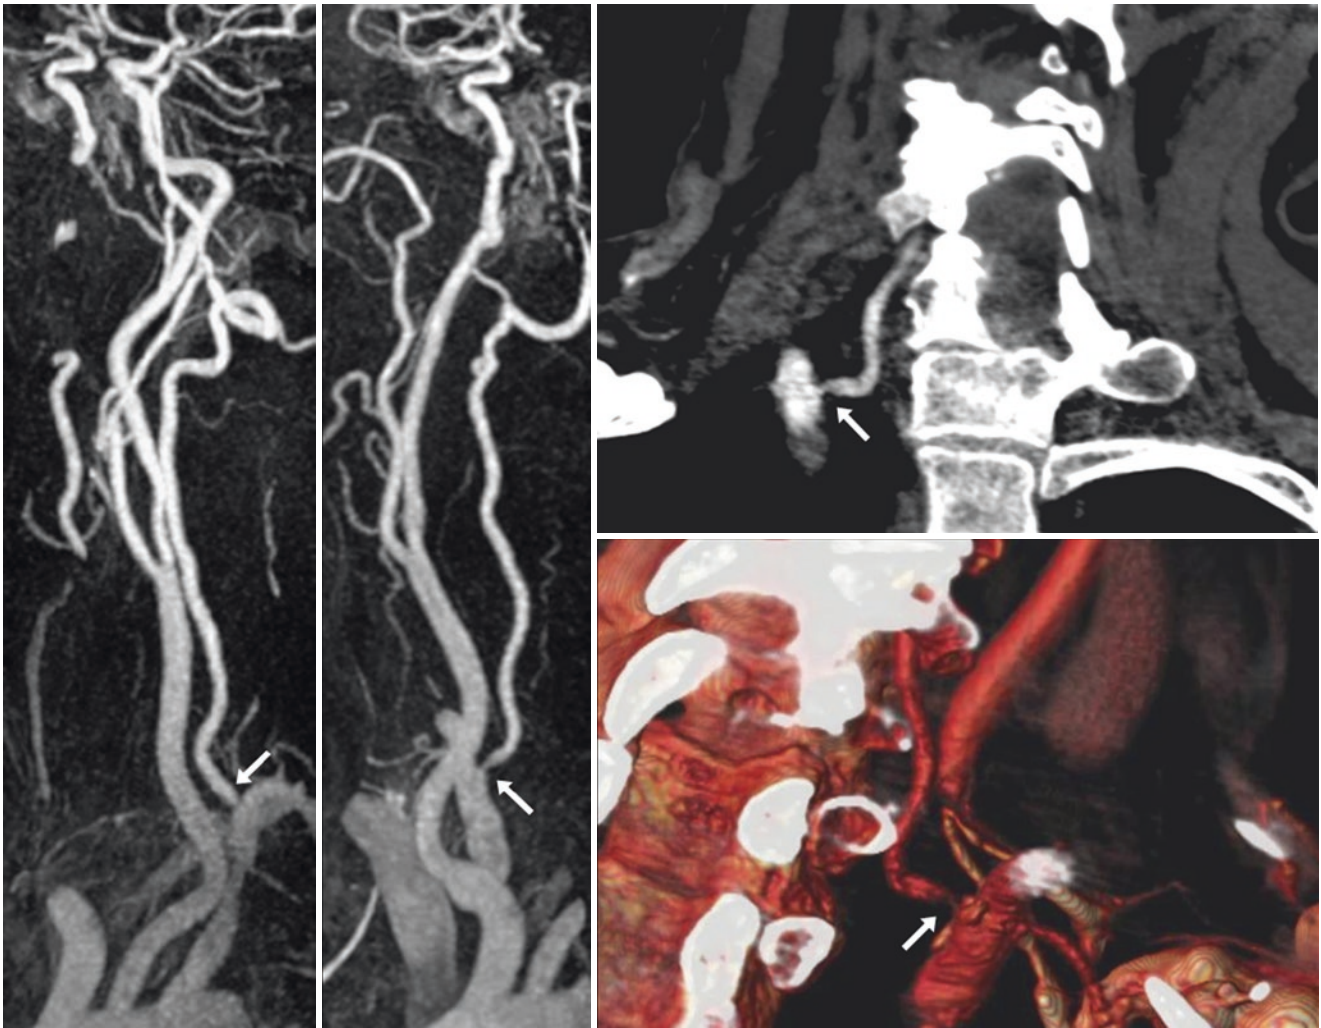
Comparison Case of Actual VA Origin Stenosis on CEMRA. 87-year-old with a right VA stenosis (arrows) suspected on CEMRA oblique views (*left* and *middle*). The stenosis is confirmed by a CTA with coronal MPRs (*right, top*) and on a 3D VR RAO view (*right, bottom*)
